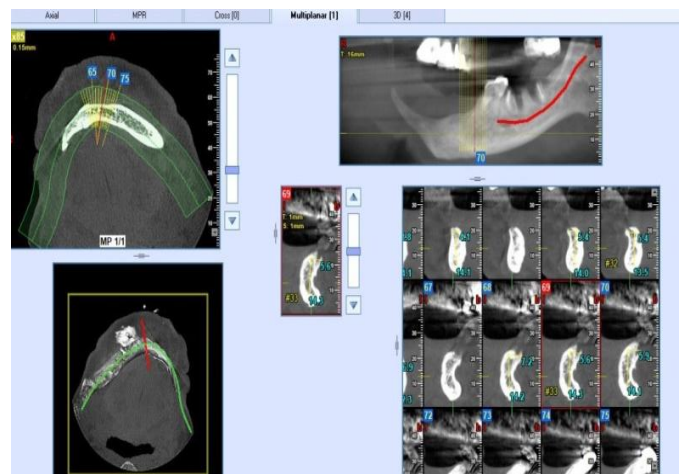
CBCT FOR IMPLANT PLACEMENT
